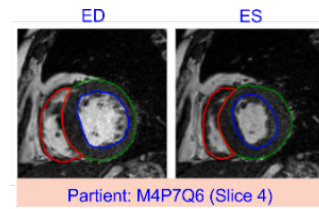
LV, MYO, RV structures on MRI
